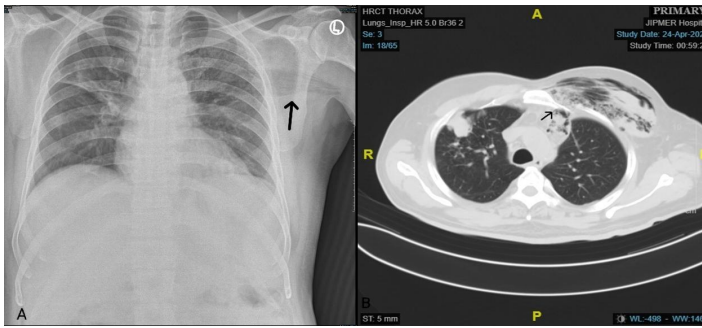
A) chest radiograph in posteroanterior view showing the left pectoralis muscle air collection (arrow), ginkgo leaf sign, and right middle zone fibrotic bands. B) High-resolution computed tomography of the chest in axial section showing pneumomediastinum predominantly over the left side (arrow), with consolidation in the right lung and air collection in the sternoclavicular joint and left pectoralis muscle.
